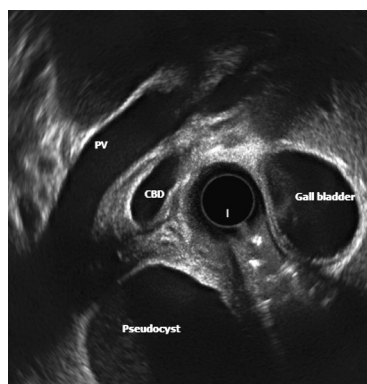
Radial EUS. Pancreatic duct could not be visualized because of presence of pseudocyst in the head of pancreas. CBD: common bile duct; EUS: endoscopic ultrasound; PV: portal vein.
